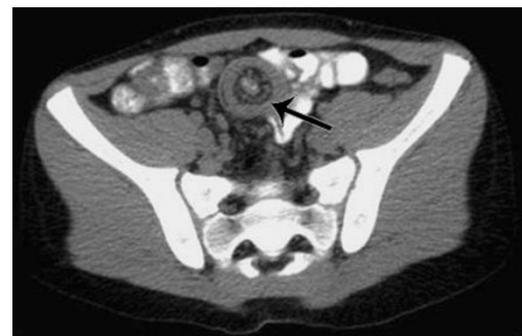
Target sign of intussusception on CT cross section
